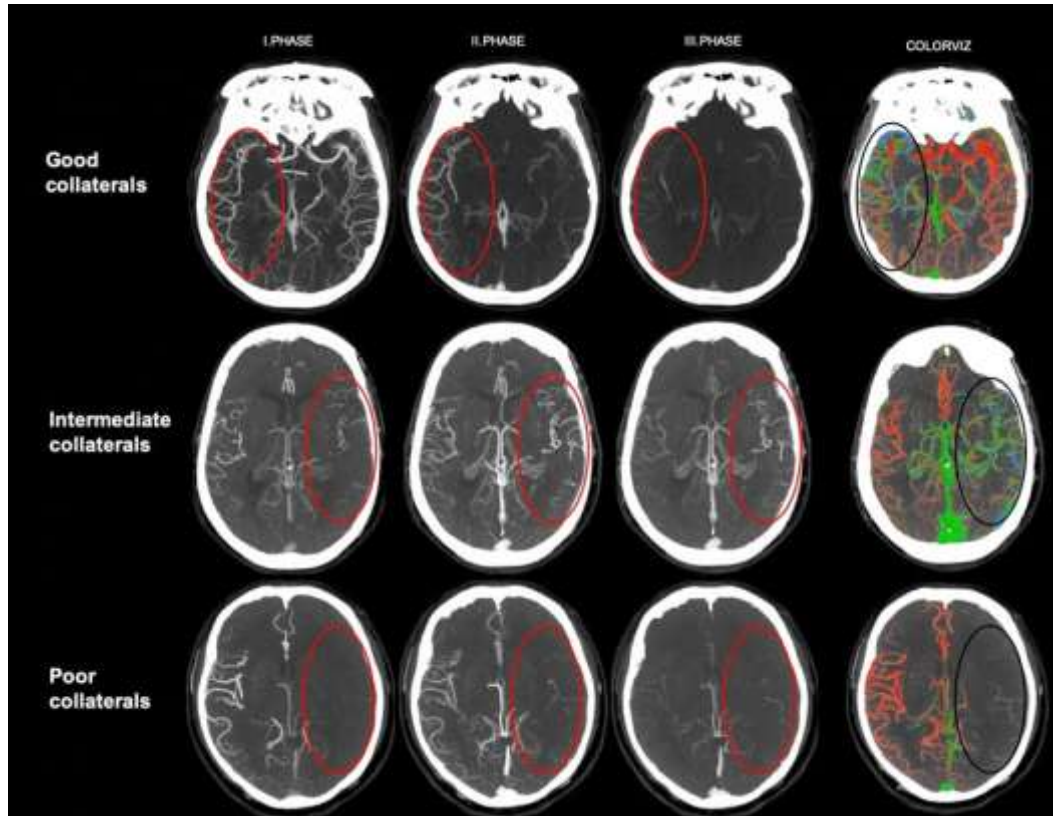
Assessment of collateral circulation with CTA
